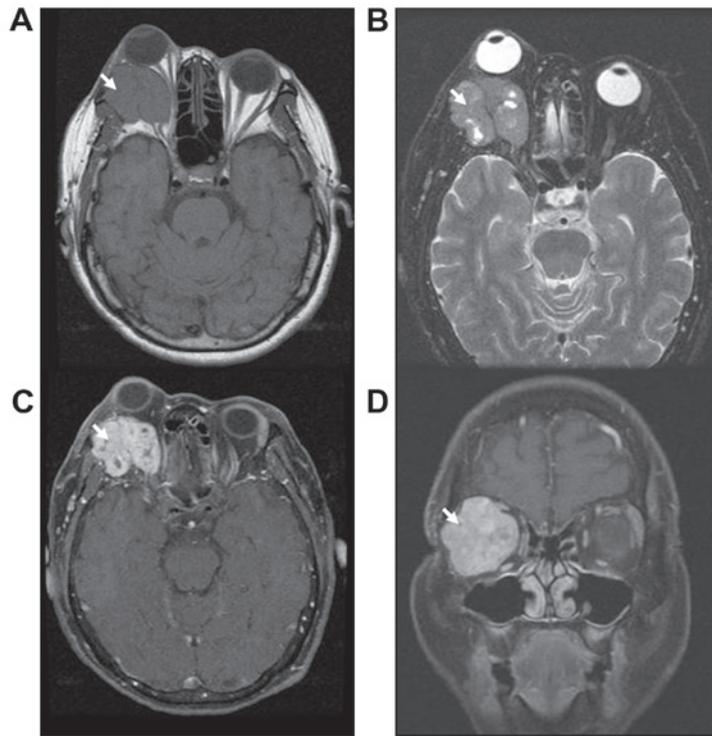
MRI of the orbit. (A) Axial T1W, (B) axial T2W with fat suppression, (C and D) axial and coronal T1W with fat suppression and gadolinium enhancement show a well-defined, lobulated, vividly inhomogeneous enhancing isosignal T1W/hypersignal T2W mass centered at the intraconal space extending into the extraconal space and invading of the lateral bony wall laterally, displacing the optic nerve medially and the globe anteriorly resulting exophthalmos.
